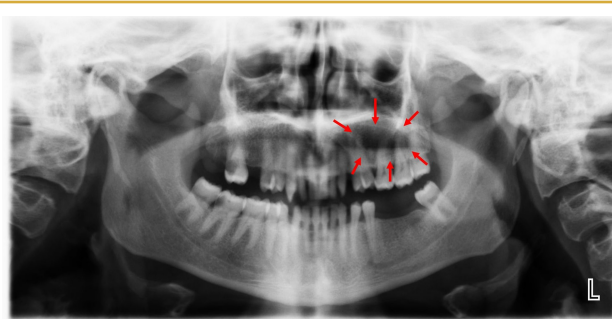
Panoramic radiography revealed a well-defined radiolucent area on the left maxillary molar region (red arrows).
